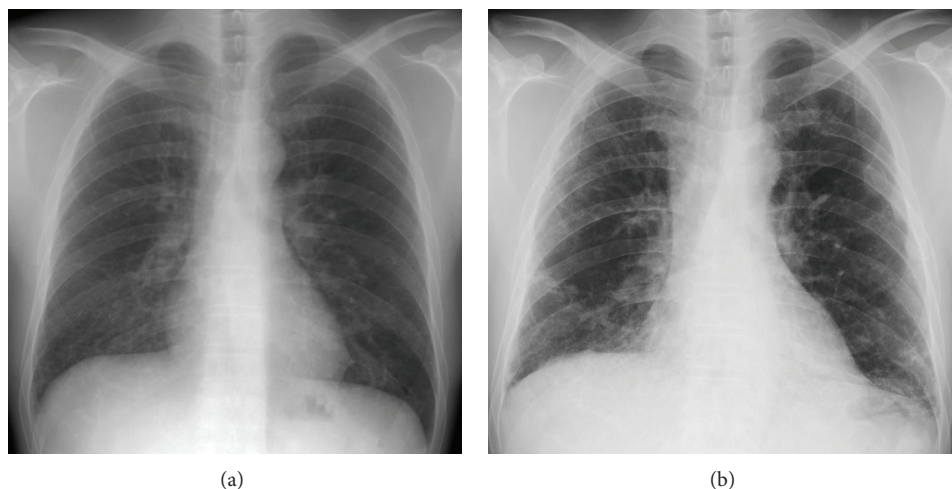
Chest X-ray at the onset of DM (a). Chest X-ray at the lung cancer diagnosis 12 years after the onset of DM (b).
